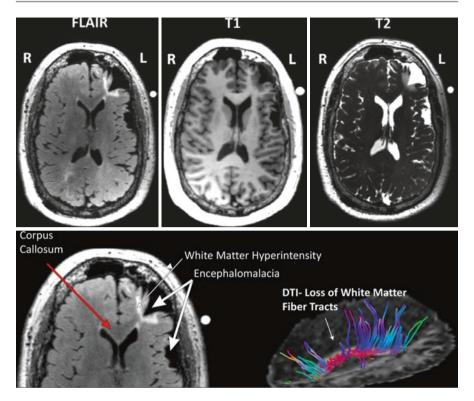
MRI 24 years after original injury. DTI tractography demonstrates a drop-out of fiber tracts across the corpus callosum
